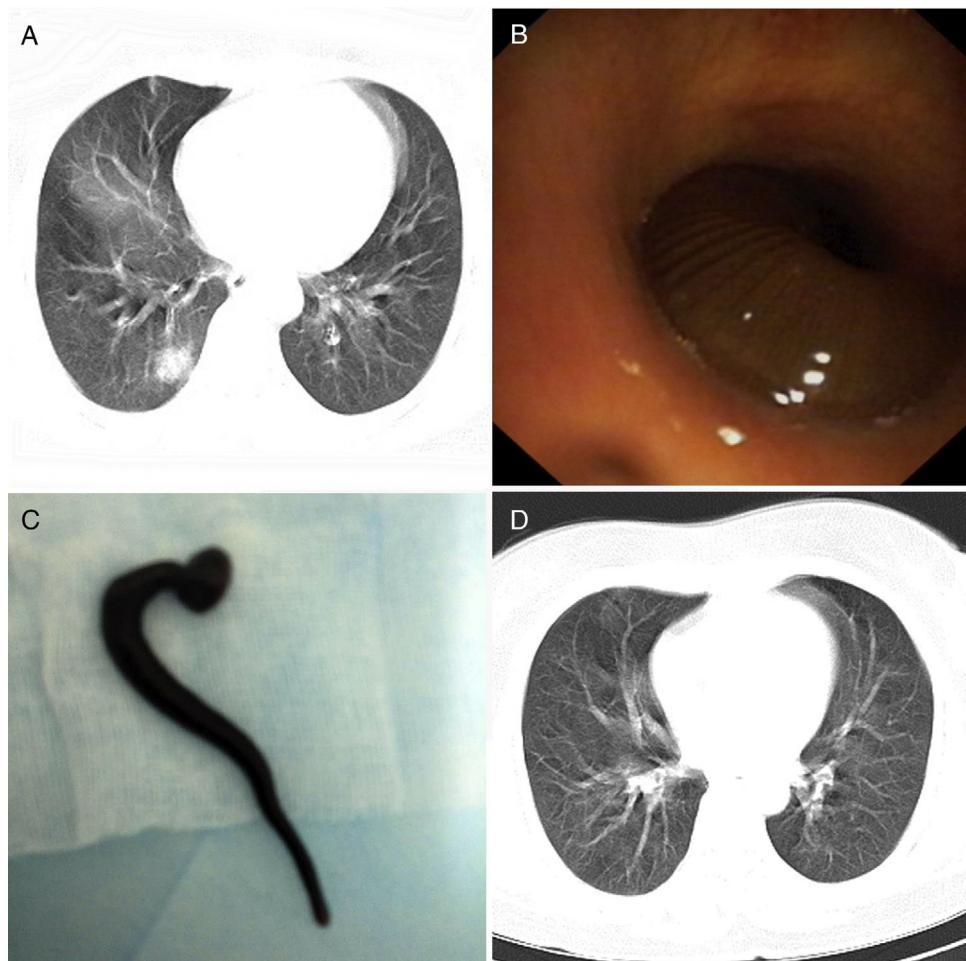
Chest computed tomography showed a ground-glass opacity in the medial basal segment of the right lower lobe (A). Bronchoscopy revealed a brown worm-like moving foreign body almost completely obstructing the lumen of the medial basal segmental bronchus of the right lower lobe (B). The foreign body was identified as a 4 cm long living leech (C). Chest computed tomography after 1 week showed the ground-glass opacity in the right lower lobe was almost completely absorbed (D).
